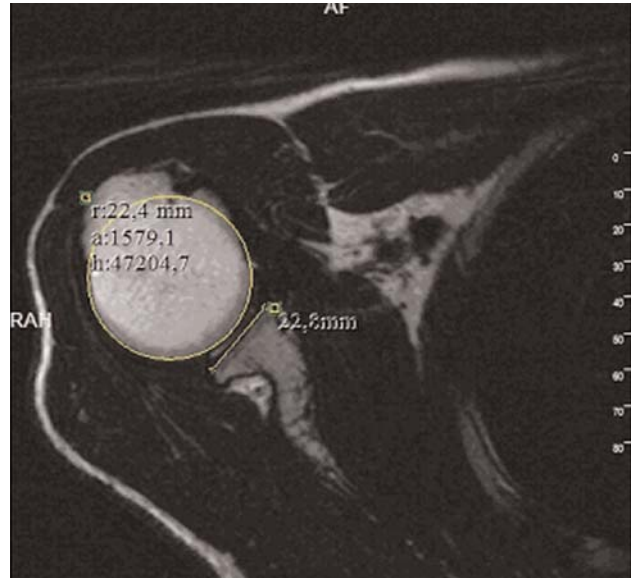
Measurement of the diameter of the humeral head (yellow circle) and the anteroposterior distance of the glenoid articular surface (yellow line) on axial T2-weighted image. [Color figure can be viewed in the online issue, which is available at www.aott.org.tr]
